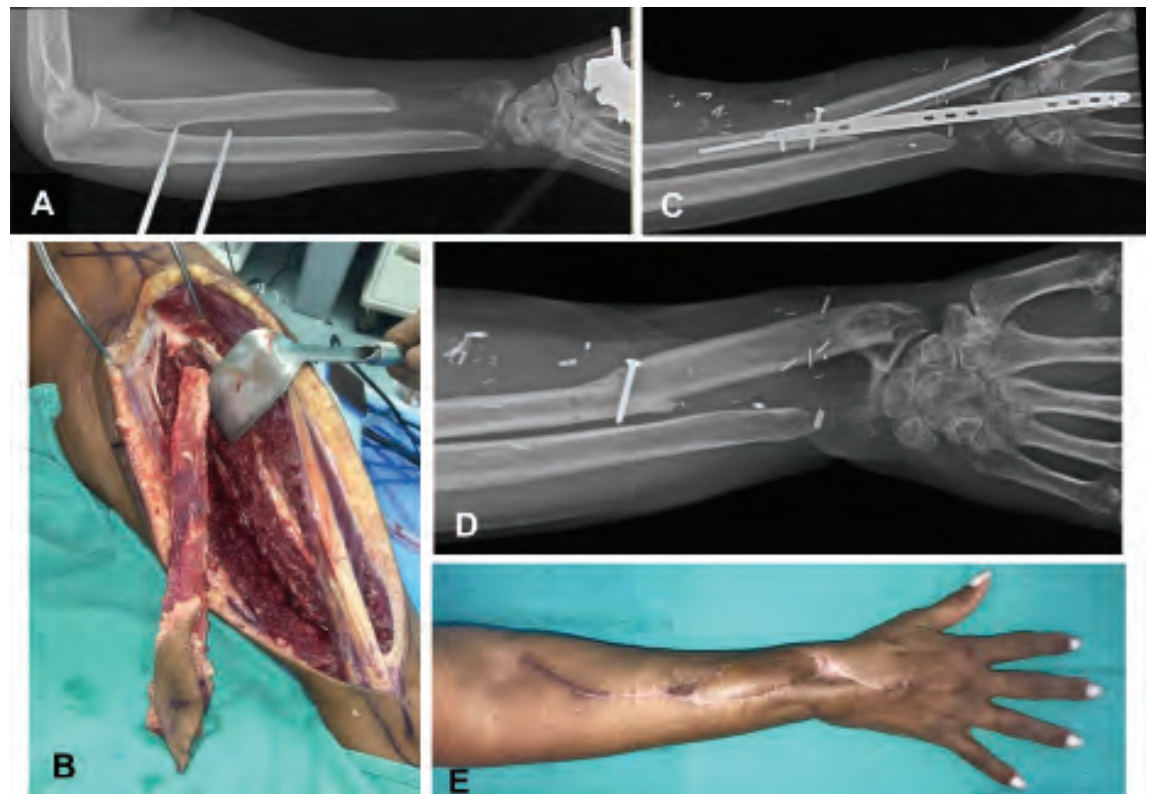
Case 1, Orthoplastic reconstruction of the forearm after an open both bone forearm fracture with an 8 cm defect of the radius (A). This was reconstructed with an osteocutaneous fibula free flap (B) and (C). Postoperative radiograph at 7 months showing bone union and a preserved radiocarpal joint (D). Post operative photograph at 5 months (E).
